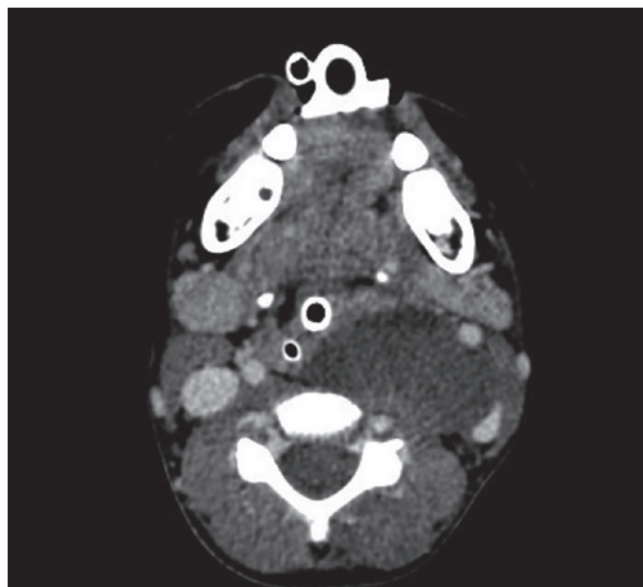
Contrast axial CT scan showing a left parapharyngeal and retropharyngeal voluminous macrocystic lymphatic malformation causing significant narrowing of the supraglottic airway.
